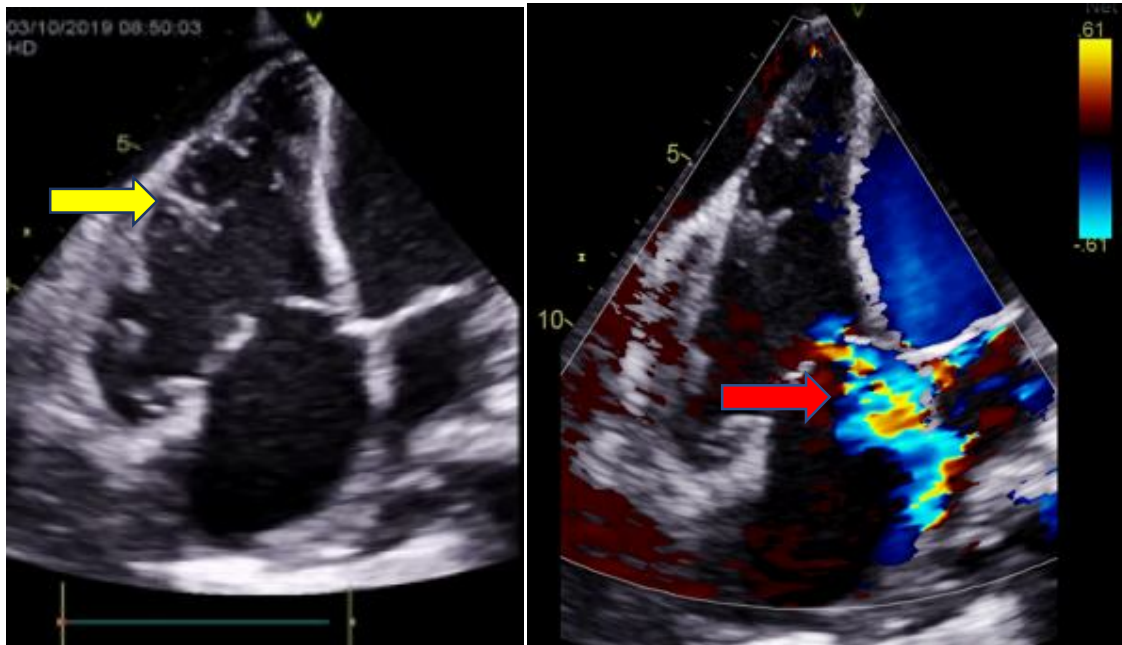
Transthoracic echocardiography (TTE): 4 chambers apical view: showing very dilated right ventricle with an aneurysm, and multiple trabeculations, in severe dysfunction (yellow arrow).
